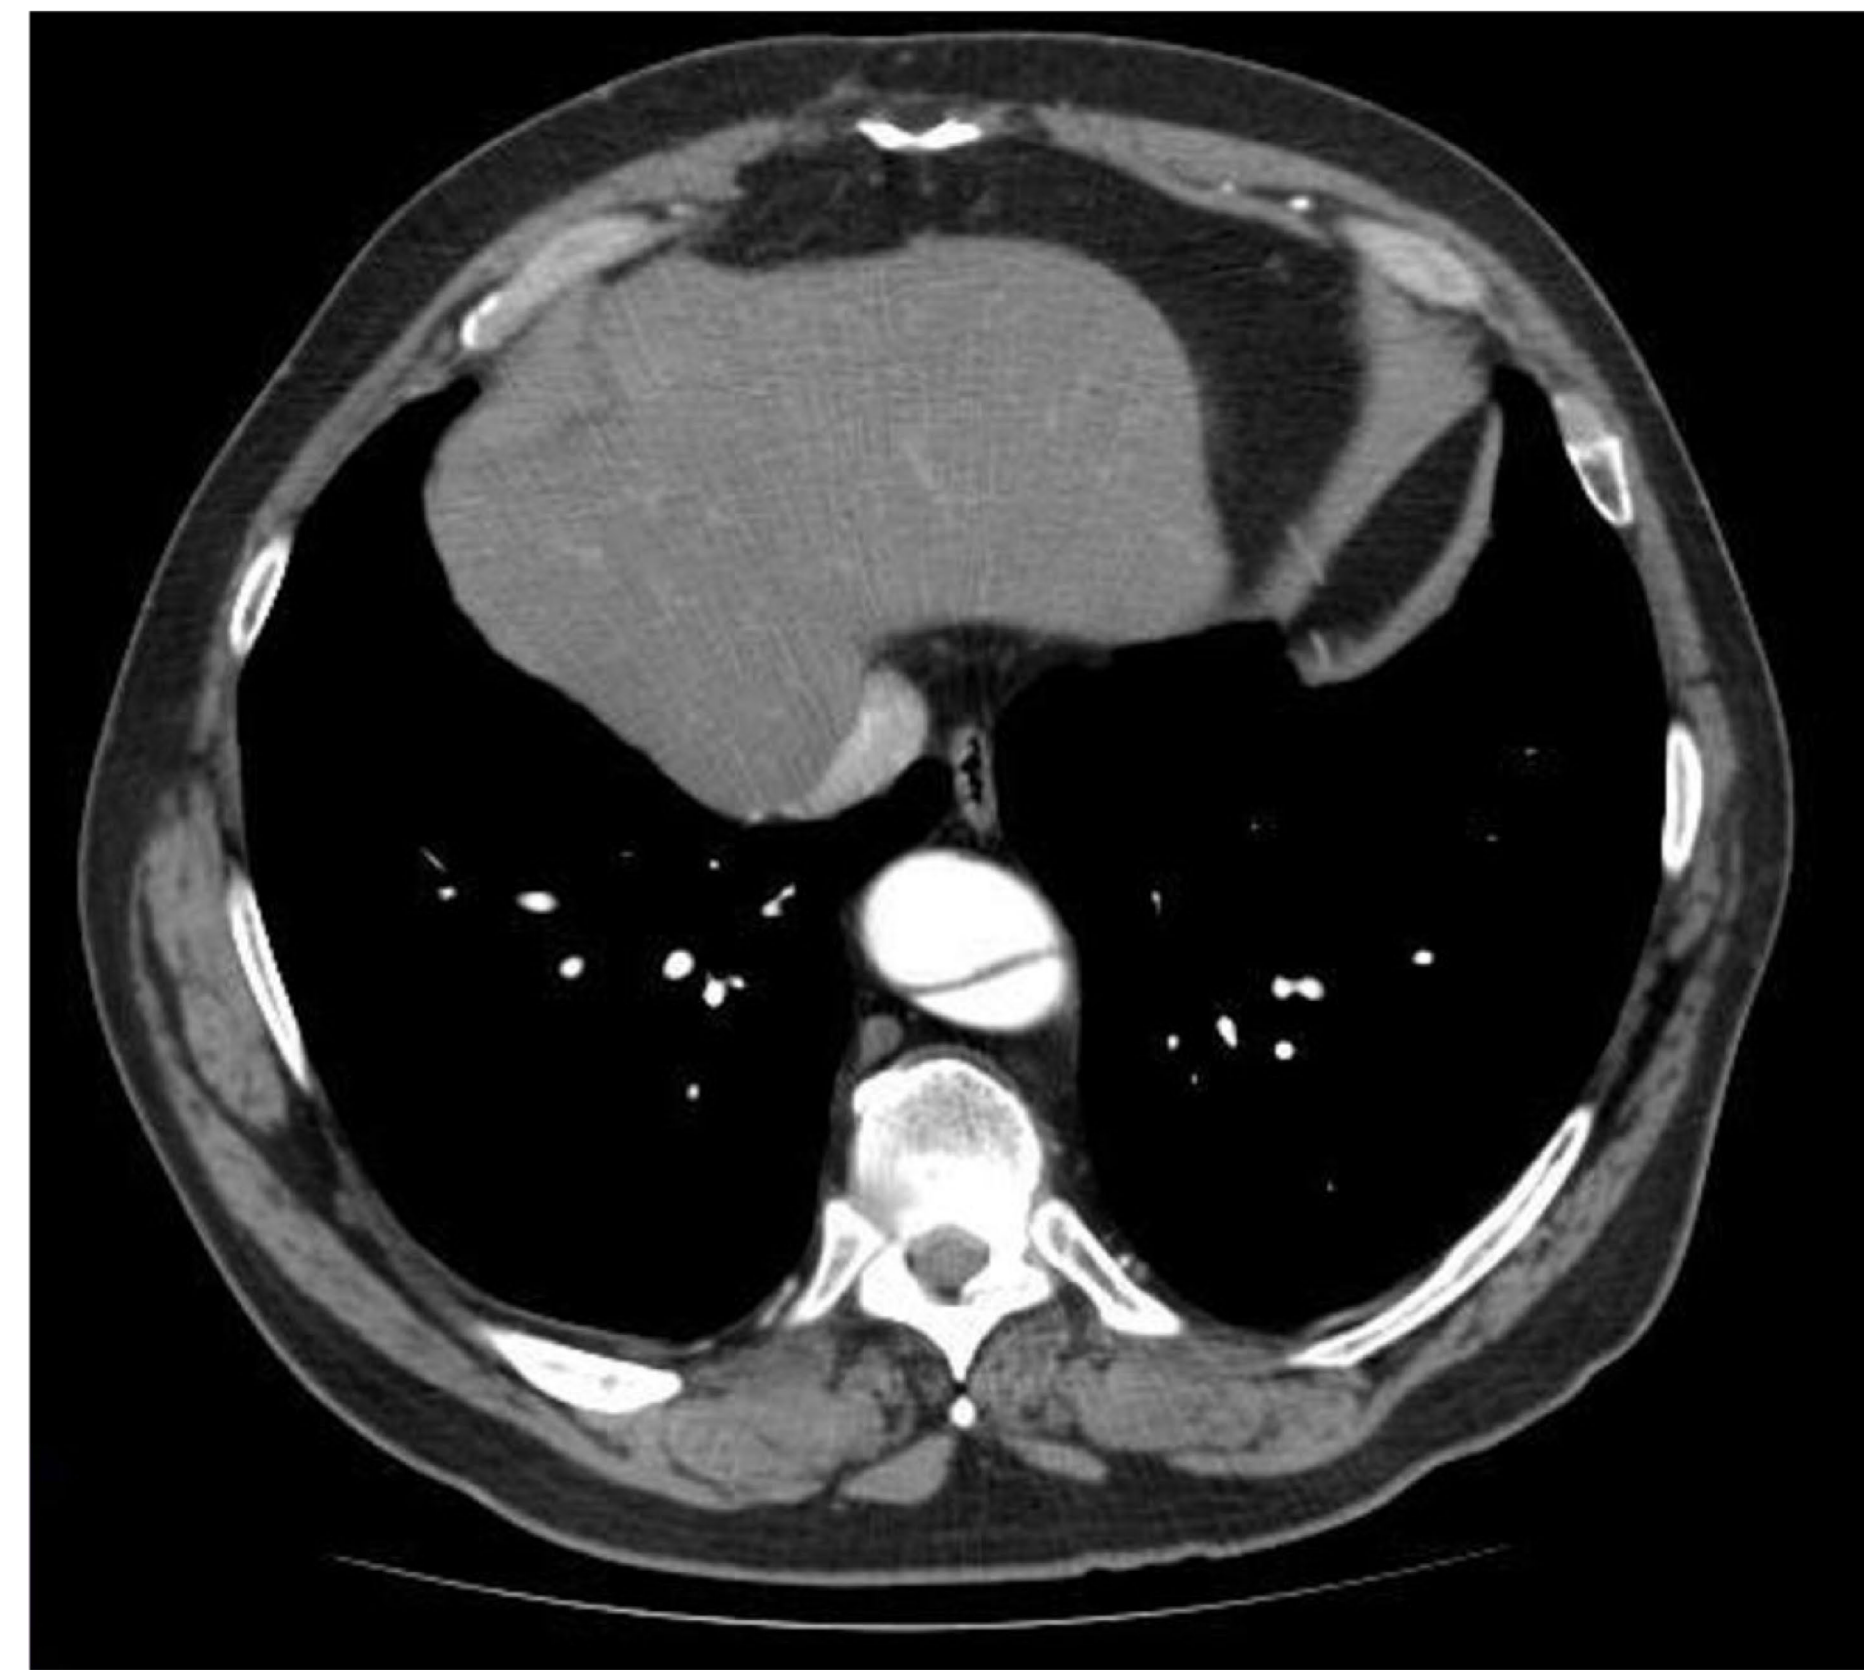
Axial section of CTA demonstrating Stanford Type B aortic dissection⁵
